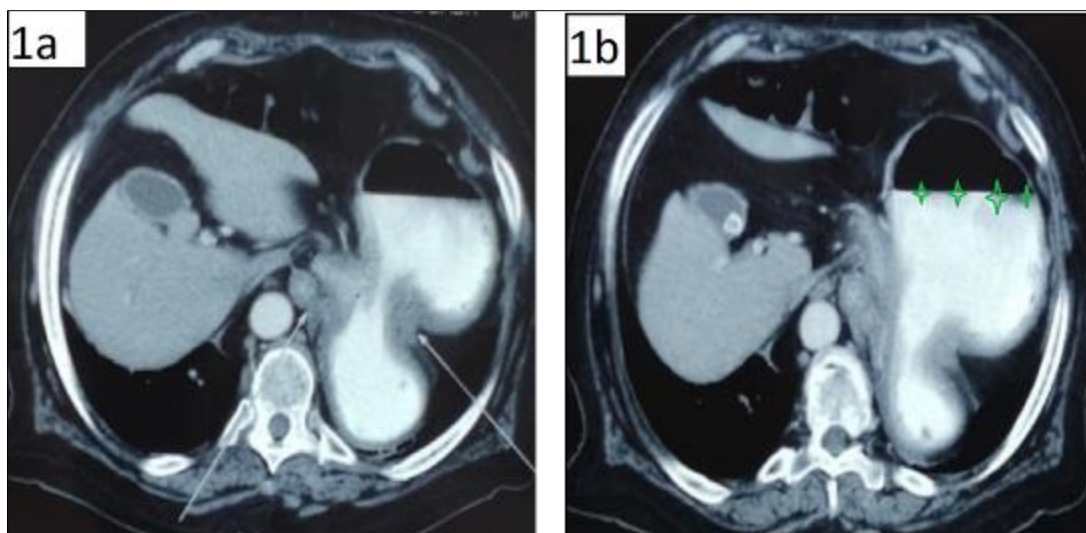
a, b Axial abdominal CT scan of the distended stomach with twisting of the gastric body (two white fleches) and upper air-fluid level (green stars)
